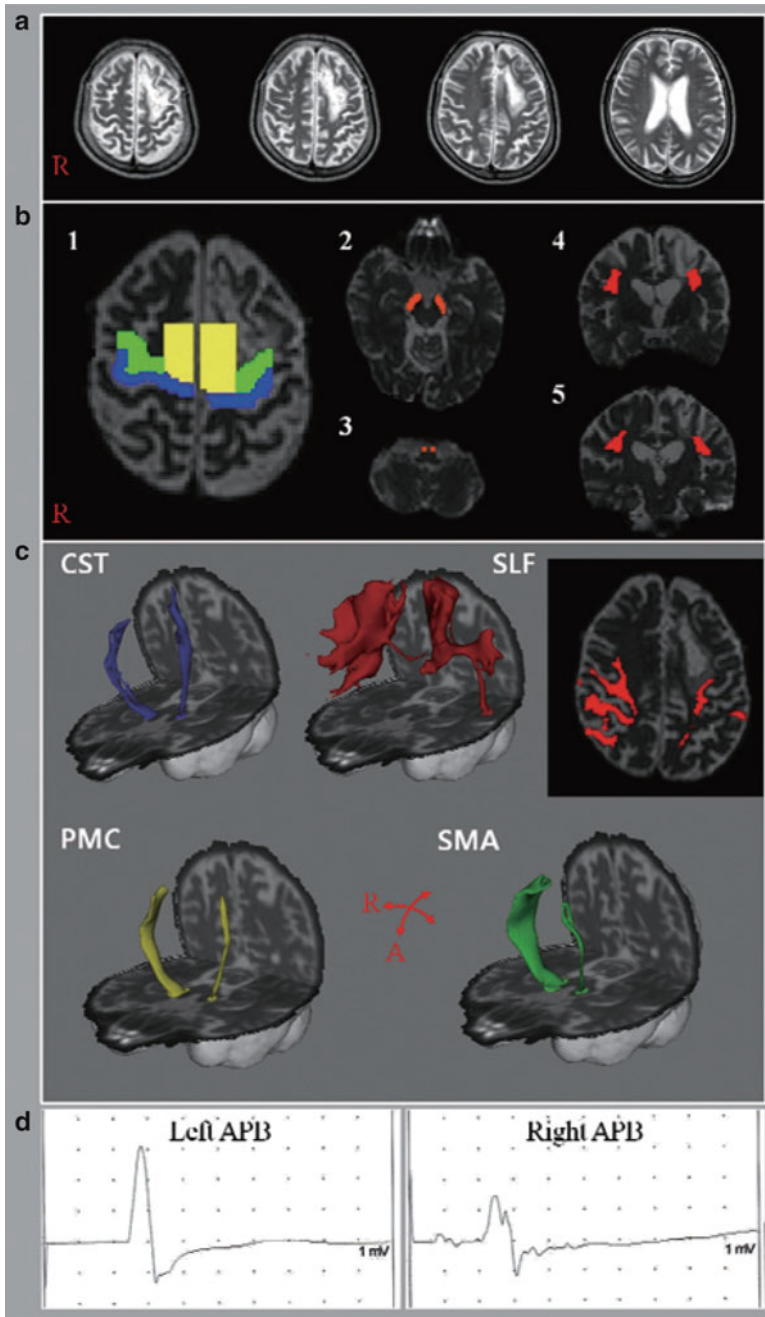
Shows T2-weighted MR images (a) and diffusion tensor tractography (c), which shows disruption to the superior longitudinal fasciculus and fibers from the premotor cortex and the supplementary motor area but intact corticospinal tract on the affected left hemisphere. Note as well the reduced amplitude of the motor-evoked potential from the abductor pollicis brevis on the right hand (left hemisphere) (Reprinted from Hong JH, Lee J, Cho YW, Byun WM, Cho HK, Son SM, et al. Limb apraxia in a patient with cerebral infarct: Diffusion tensor tractography study. *NeuroRehabilitation*. 2012;30:255–259, with permission from IOS Press)
